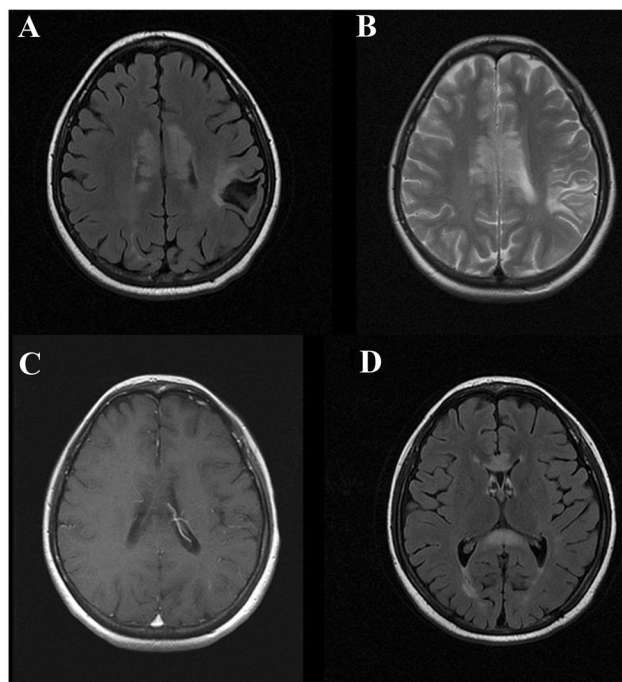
Callosal lesions with “arch bridge” and “marbled patterns”. Callosal hyperintensity in FLAIR (a) and T2-weighted (b) showed a “marbled pattern”, without contrast enhancement (c). The complete thickness of genu and splenium hyperintensity revealed an “arch bridge pattern” with periependymal involvement on FLAIR (d). Note there existed encephalomalacia in the left parietal lobe but with no clinical history (a). *FLAIR* fluid-attenuated inversion recovery
